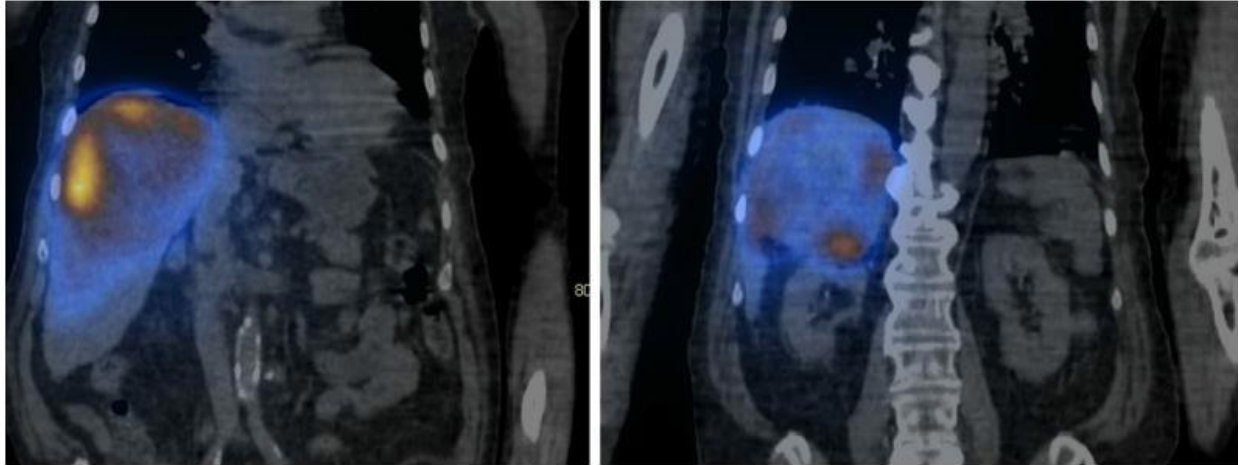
Coronal SPECT Post Second-Y-90 therapy
